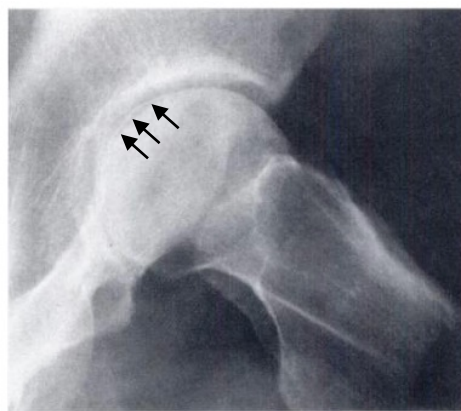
Radiograph showing the crescent sign (arrows) (Steinberg *et al.*, 1995). *Reproduced with the permission of Dr. Steinberg.*
